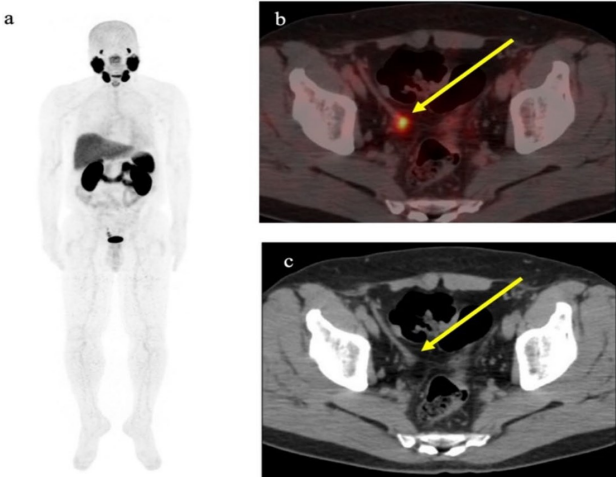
PSMA PET-CT imaging of a patient with biochemical recurrence of prostate cancer revealed focal radioactivity uptake extending from the right seminal vesicle to the vas deferens area. Notably, no significant radioactivity accumulation was detected in other regions, which is indicative of metastatic spread. (a) Maximum intensity projection image. (b) Transaxial PET/CT fusion image. (c) Transaxial CT.
